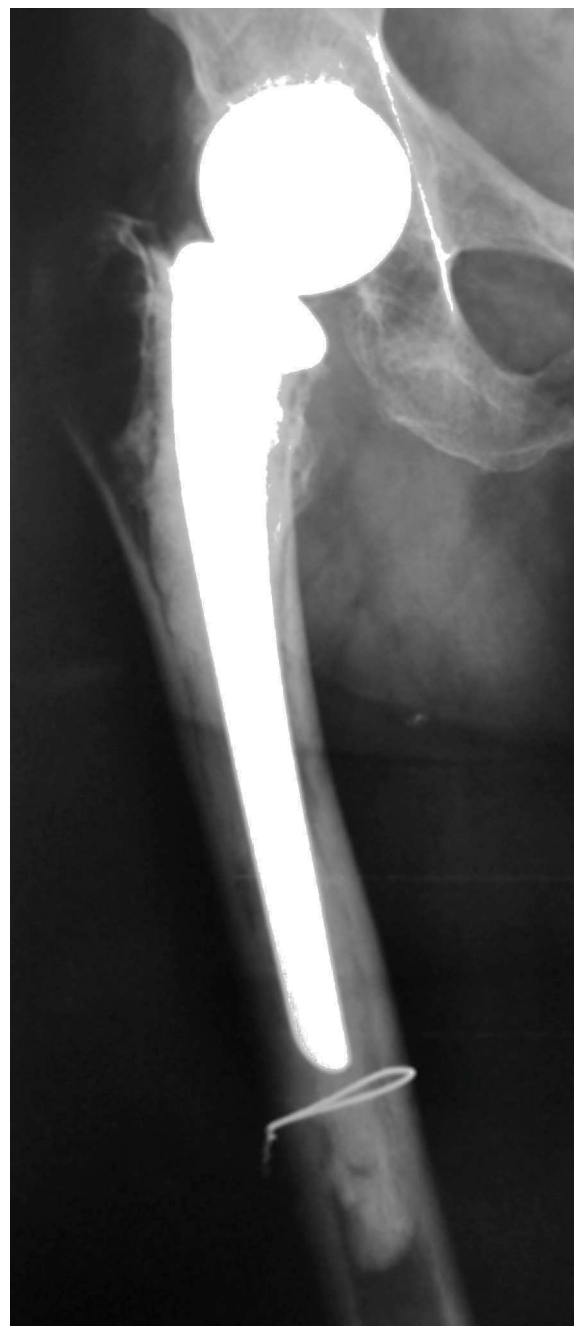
X-ray of hip prosthesis.
